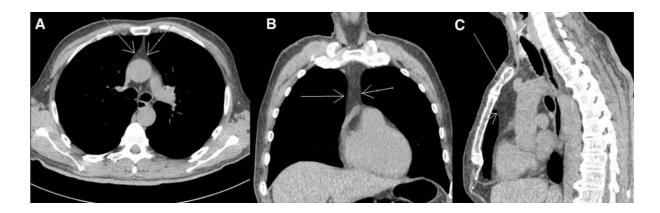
Chest CT in Case 1
